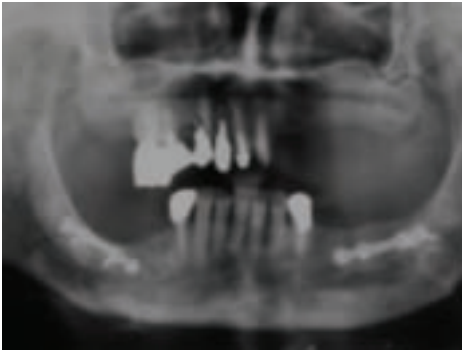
Radiographic situation. Titanium plates had been inserted in the posterior regions of the mandible.
